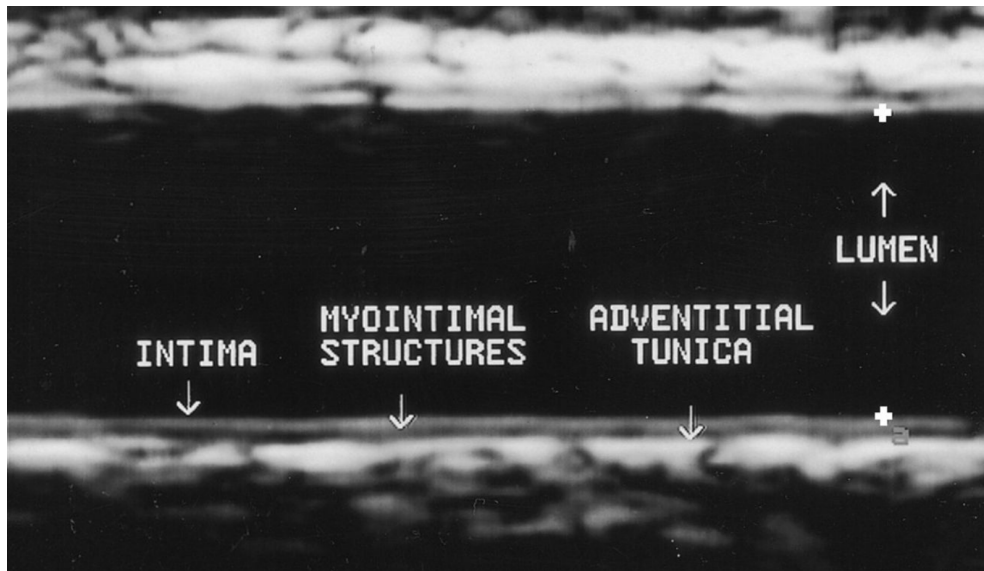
Carotid endothelial structures by B-mode ultrasound.
